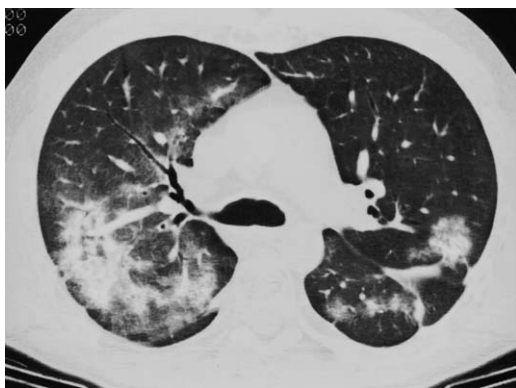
CMV pneumonitis in a 44-year-old man after bone marrow transplant. HRCT image through the upper lobes shows patchy areas of ground-glass attenuation and consolidation in both lungs, greater on the right.
